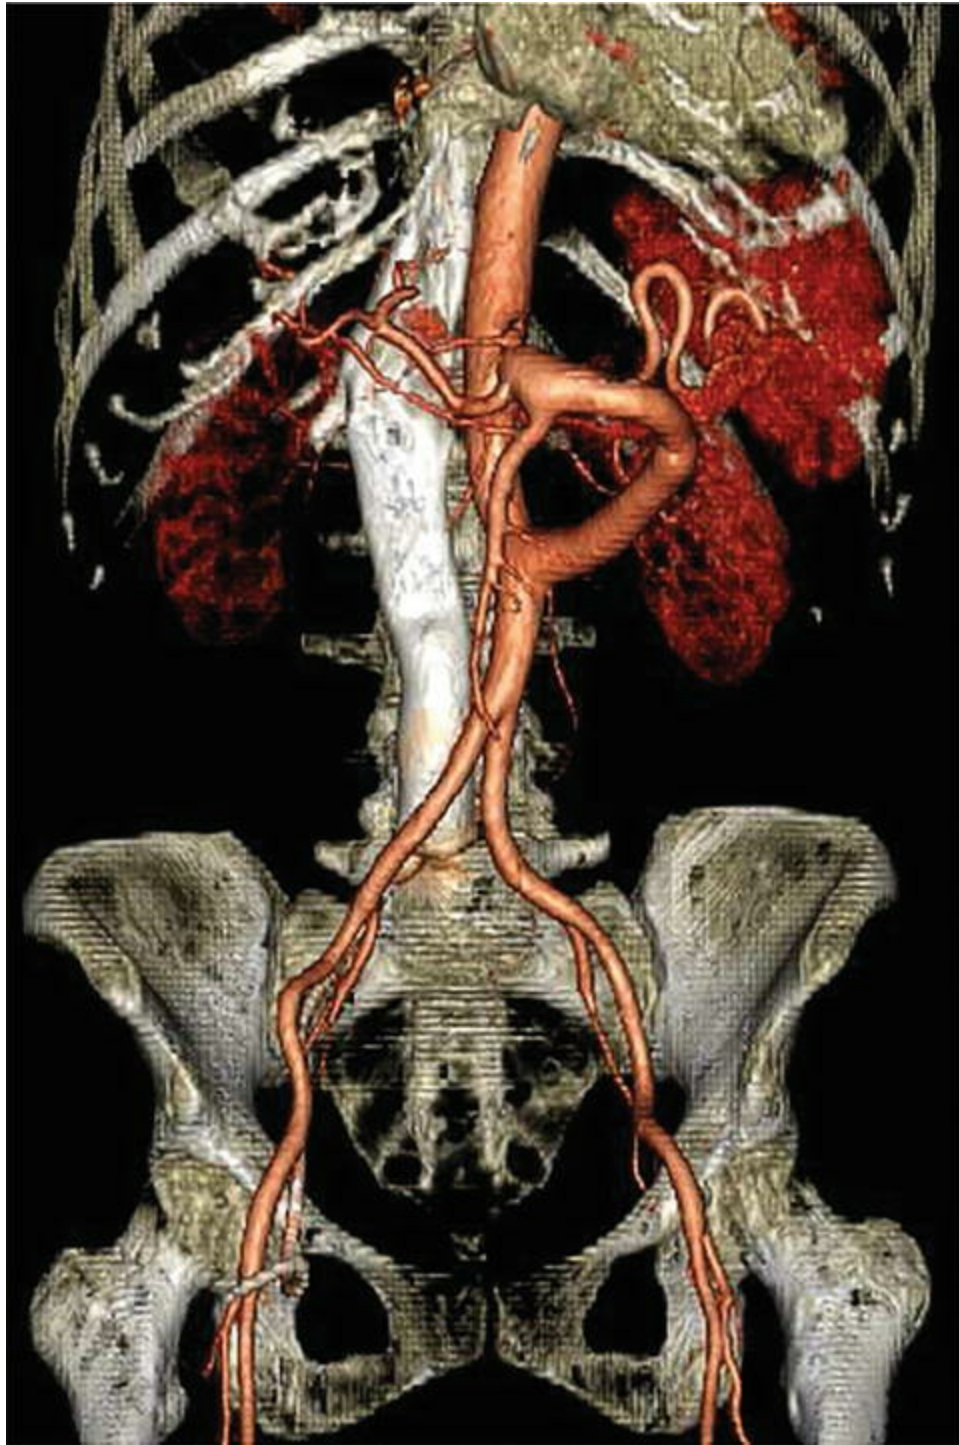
3-D computed tomography of an infrarenal aortic graft with a single common conduit of a Carrel patch containing both the celiac artery and SMA
